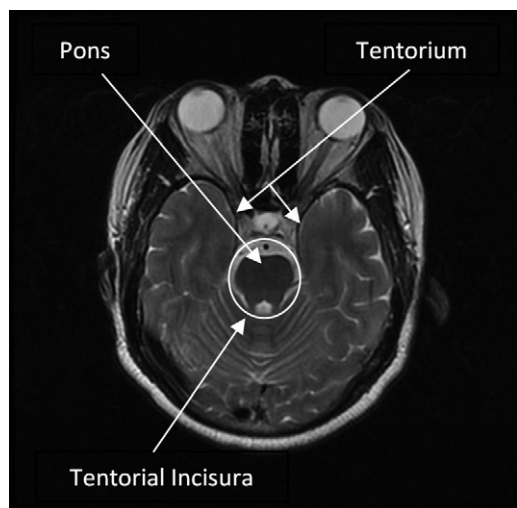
T2-weighted axial-plane magnetic resonance images demonstrating the brainstem passing through the tentorial incisura. The tentorium is seen as the black bands along the medial border of the temporal lobes. The superior portion of the cerebellum is posterior to the pons.
